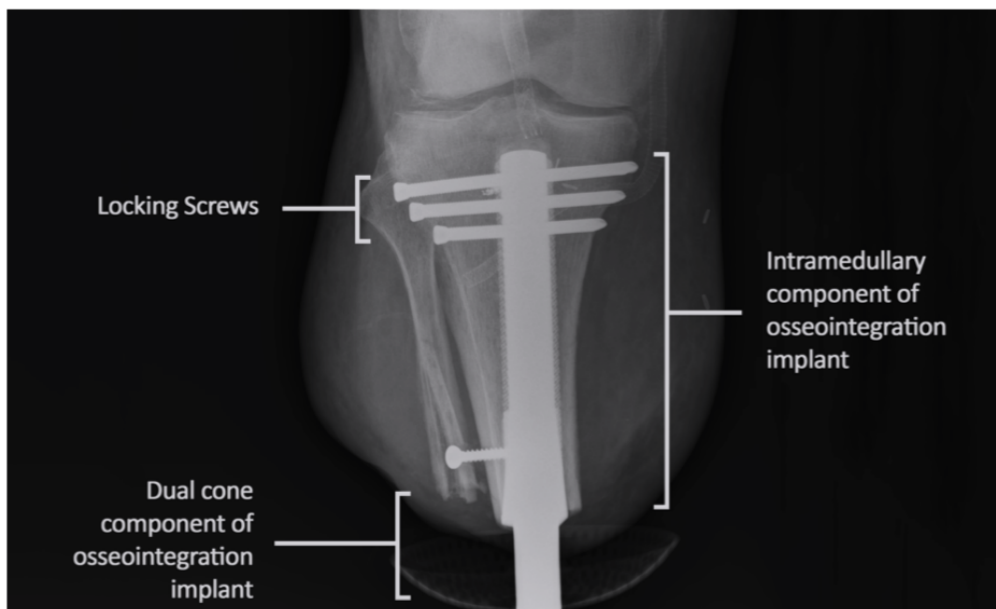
Radiograph of a transtibial implant showing the rough surface structure of the implant and three proximal cross fixation screws.
